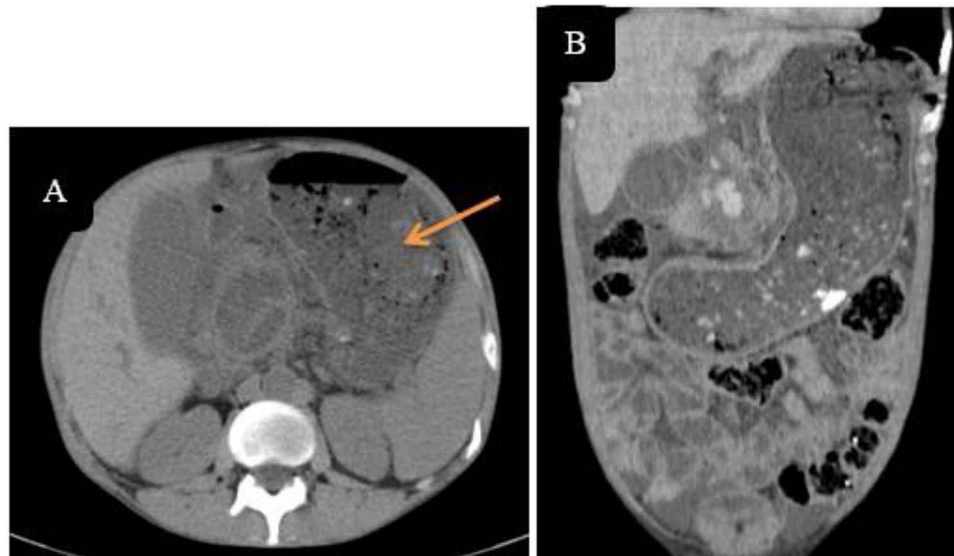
Non-contrast CT (A) axial and (B) coronal; showing a dilated stomach with heterodense contents. Orange arrow in (A) indicates the gastric bezoar.
